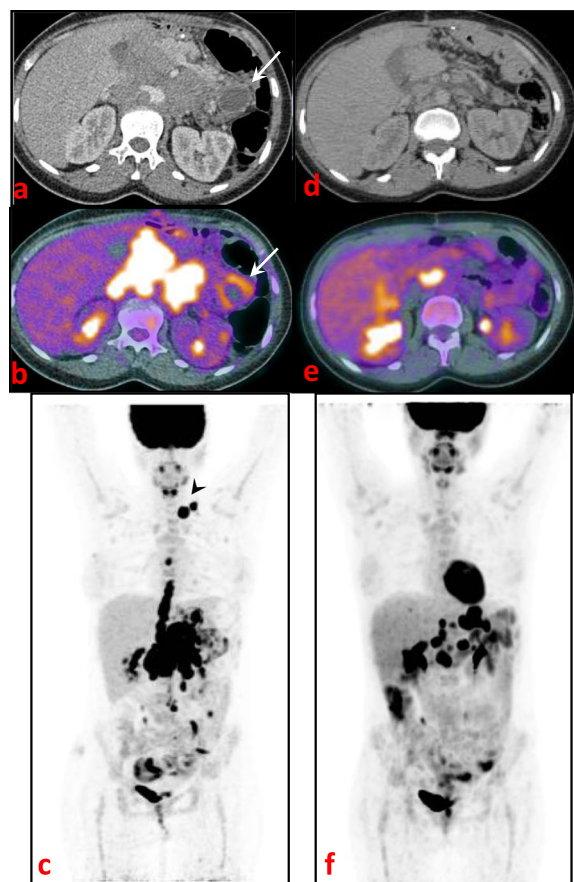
Axial CT, axial fused, and coronal MIP images for a 60-year-old female presenting with total gastrectomy, splenectomy, and distal pancreatectomy for gastric adenocarcinoma received chemotherapy (a and b) showed encysted collection seen at the operative bed with marginal FDG uptake (white arrows). (c) Showed left supra-clavicular lymph nodes (black arrow-head), mediastinal, abdominal, and pelvic lymph nodes. (d, e, and f) during 3-month interval follow-up after chemotherapy showing resolution of operative bed encysted collection, marked response of the metastatic lymphadenopathy. Thus, final diagnosis approved by clinical and radiological follow-up after chemotherapy
